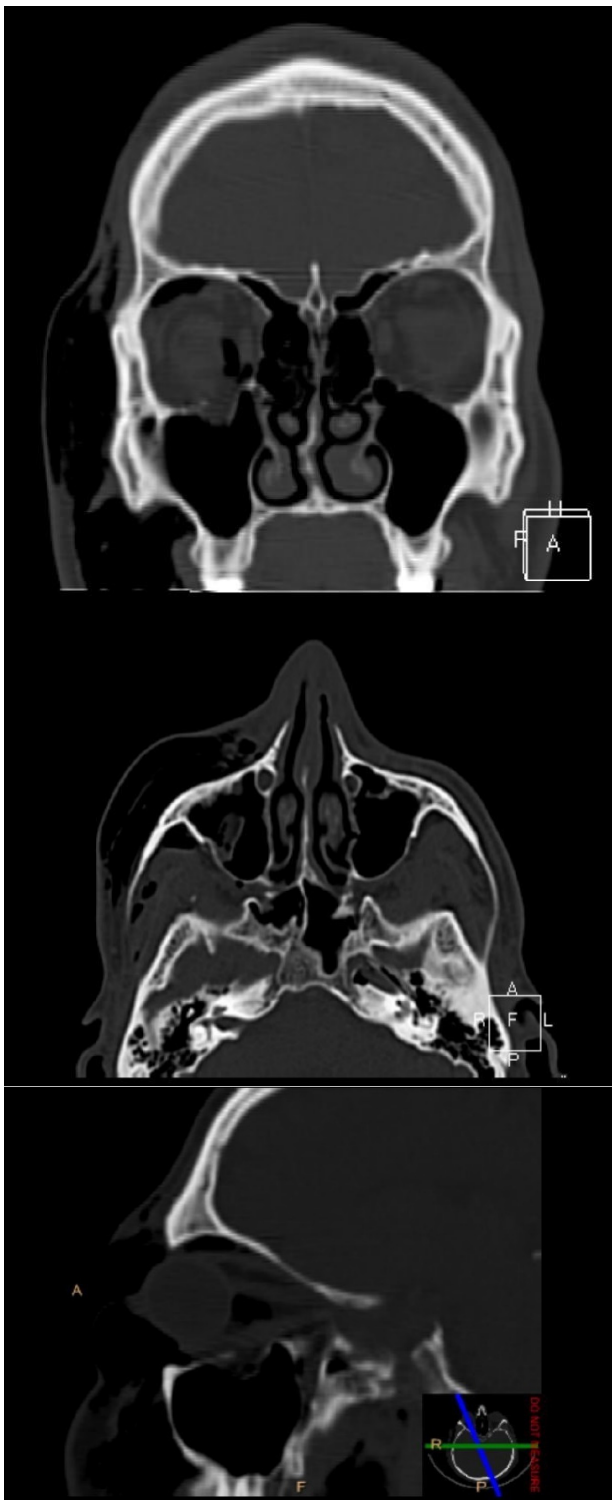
Coronal, Axial and sagittal bone window computed tomography of the face demonstrates mildly displaced orbital floor fracture, subcutaneous air in the right orbit as well as extensive right premaxillary and peri-orbital soft tissue.
